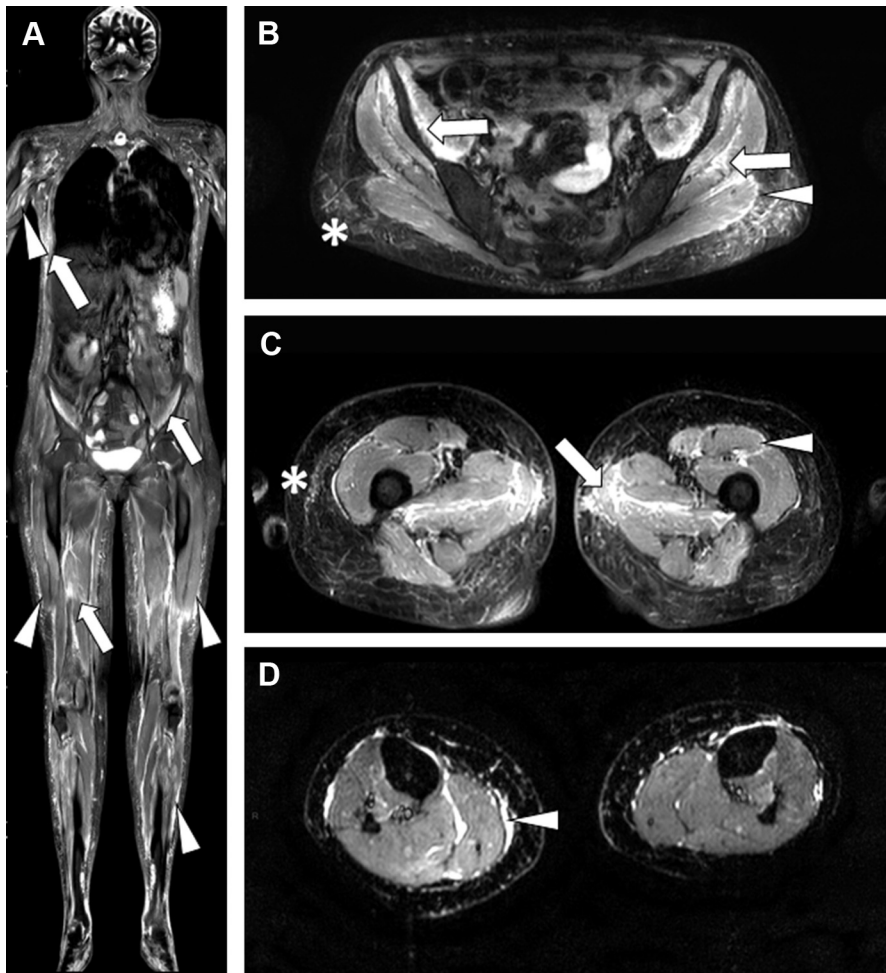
WB MR imaging from a 53-year-old woman with a severe form of diffuse SSc with myocardial and pericardial involvement, presenting with tendon friction rubs, synovitis, tenosynovitis, and reduced range of motion in shoulders and ankles. Coronal (A) and transverse (B–D) STIR MR imaging reveals extensive musculoskeletal involvement with concurrent involvement of the muscles (arrows), fascias (arrowheads), and subcutaneous tissue at the level of the scapular and pelvic girdles (asterisks), thoracic and abdominal walls, and lower limbs.
